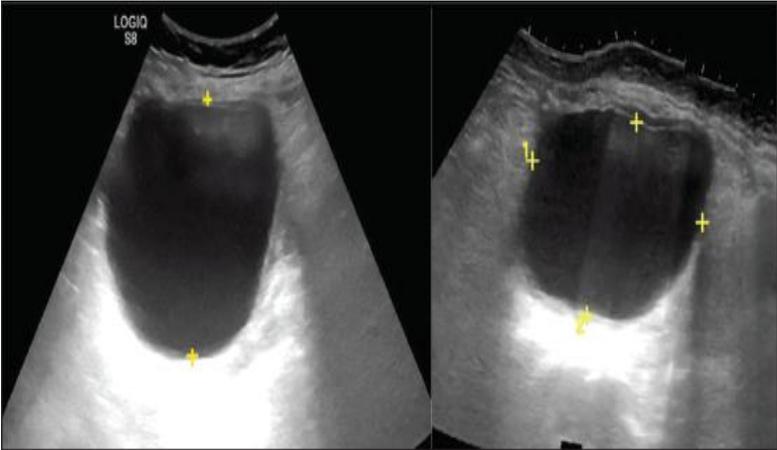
Three distinct individuals' cystic adnexal lesions on ultrasound (USG) pictures display various forms of locularity. Bilocular, multilocular, and unilocular
